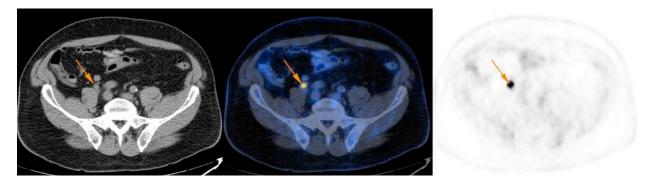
Metastatic right internal iliac lymph node in a 64-year-old men operated 2 years ago from a right thigh melanoma 3.1 mm Breslow index. Preoperative hybrid CT (left), PET/CT (middle) and PET (right)
